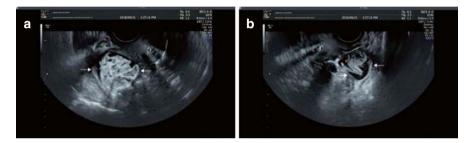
(a) 2D B-mode ultrasound showing contrast agent aggregates in the enlarged right fallopian tube (arrows indicate the aggregates). (b) 2D B-mode ultrasound showing contrast agent aggregates in the enlarged left fallopian tube (arrow indicates the aggregate)
